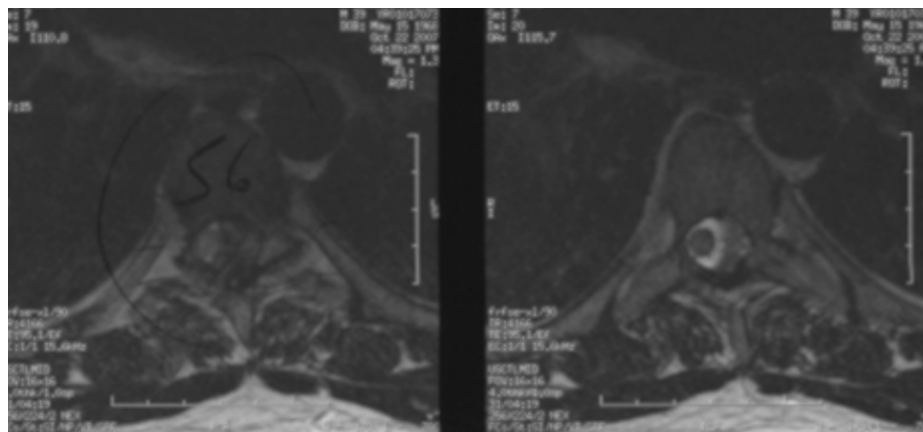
Axial T2 magnetic resonance imaging showing cord compression at the T5/T6 level.
